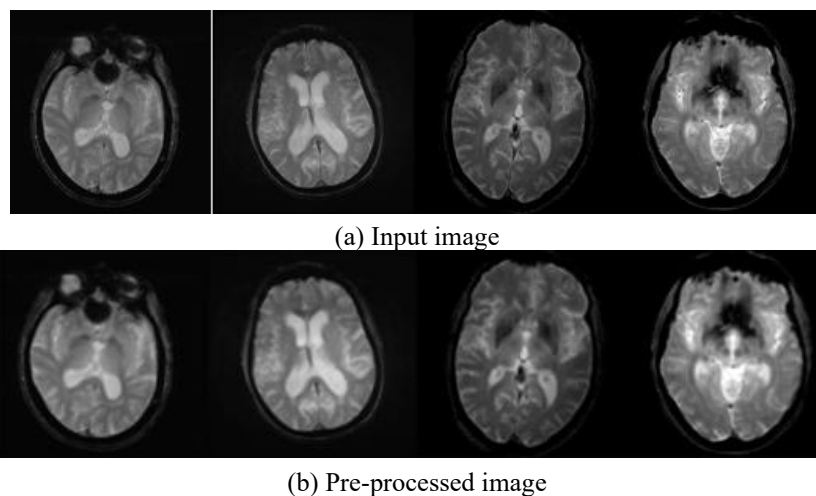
Sample ADNI MRI Images for AD Classification
